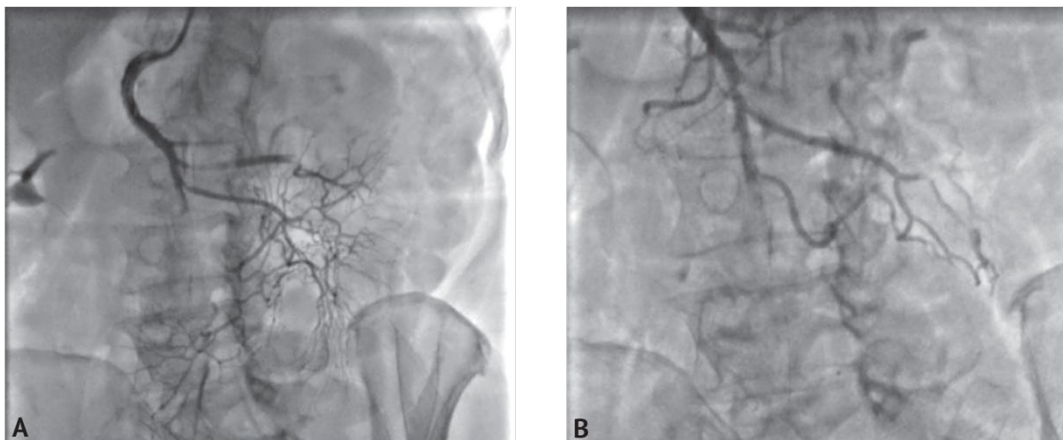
Intraoperative photo. Computed tomography angiography visualizes occlusion of the superior mesenteric artery (A); the area of occlusion of the distal superior mesenteric artery is visualized (B)
